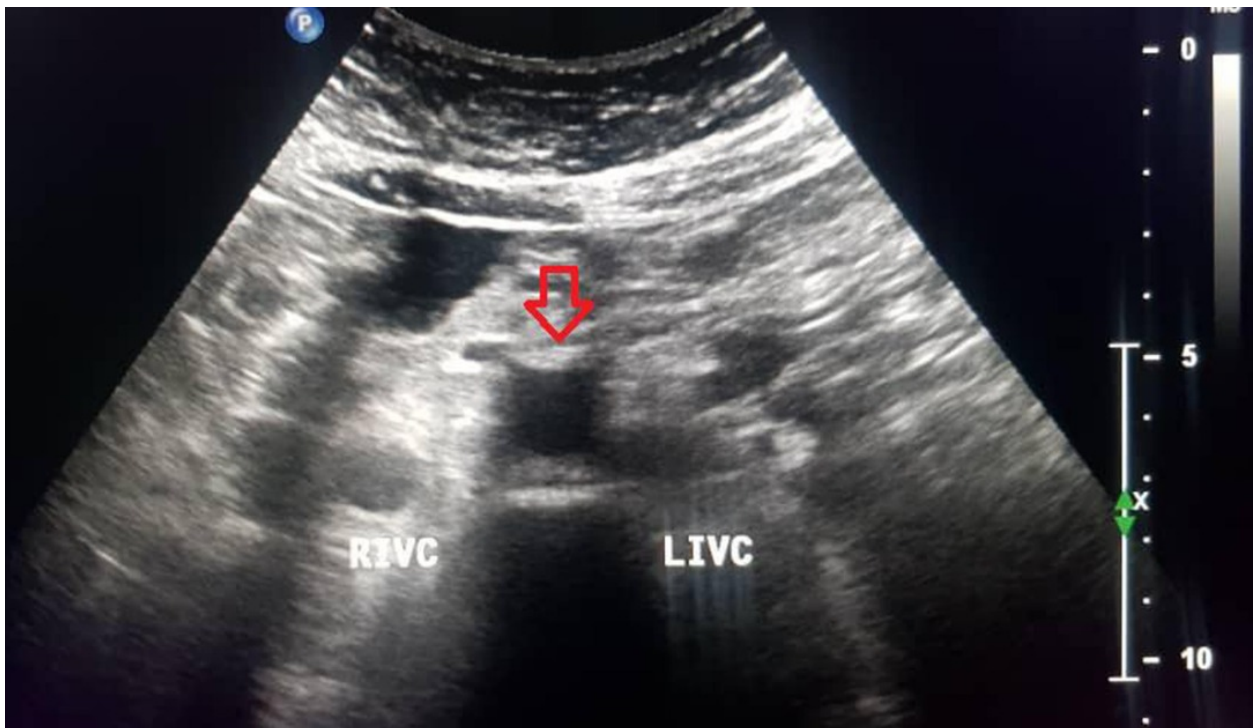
Abdominal ultrasound showing the aorta in the center of the image with an open arrow and double IVC on both sides of the aorta
